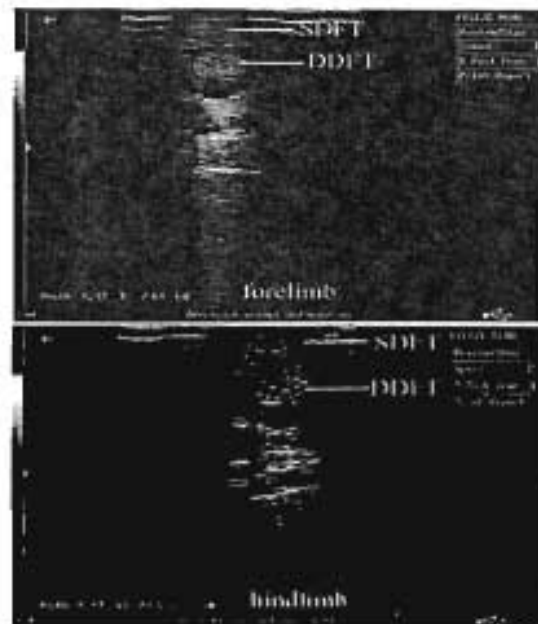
longitudinal sonogram of the normal flexor tendons in the proximal metacarpal region (A) and metatarsal region (B) showing the relation between the SDFT and DDFT in the fore and hind limbs.
